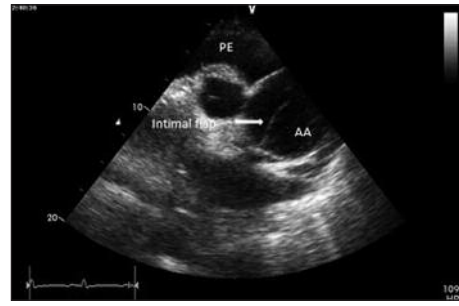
Modified parasternal long axis view of two dimensional transthoracic echocardiography demonstrating intimal dissection flap.
